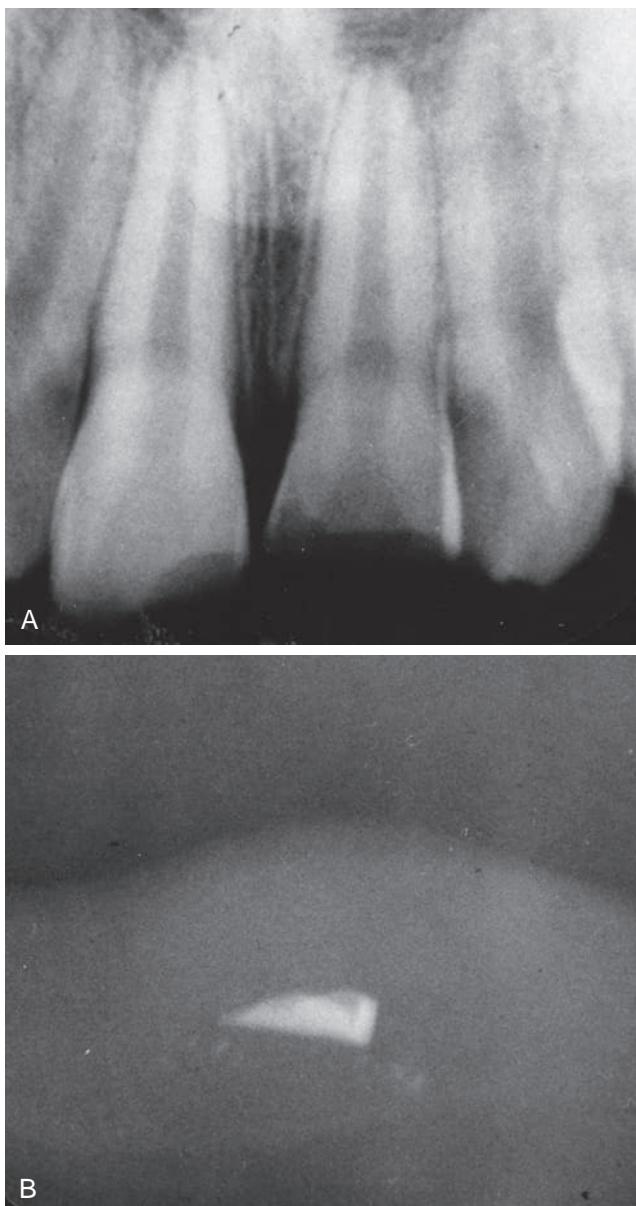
(A) Radiograph of fractured teeth. (B) Radiograph with a reduced exposure time (25% of the usual time) was useful for detection of the location of this fractured tooth fragment within the patient's lip.
